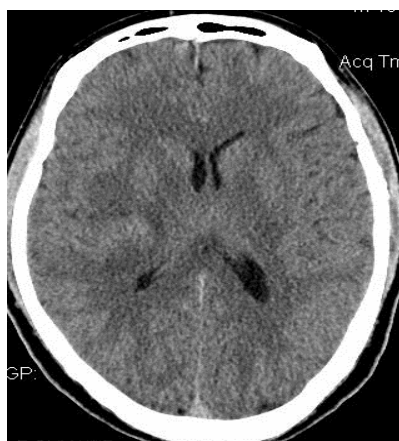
CT scan. A right parietal region of low density is present with mass effect, without calcification or hemorrhage. A small curvilinear region of increased density is noted, which is of uncertain significance. The final diagnosis was diffuse astrocytoma (WHO grade II). CT: Computed tomography.
